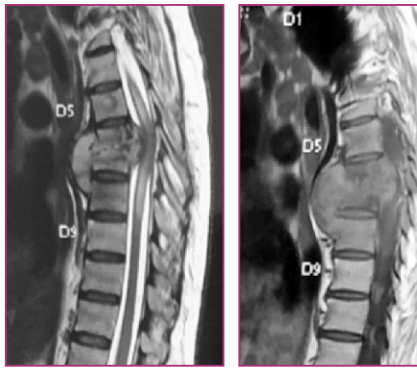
(B) MRI T2W, T1W
